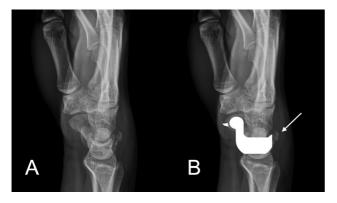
Lateral radiograph of the right wrist showing a bony avulsion of the dorsal triquetral bone (A). The "pooping duck" sign is created by the confluence of the bone images of the proximal carpal row of the carpus: the scaphoid (head and neck), lunate (body and wings), and the dorsal cortex of the triquetrum (tail). The dorsal fracture fragment represents duck droppings (arrow) (B).
